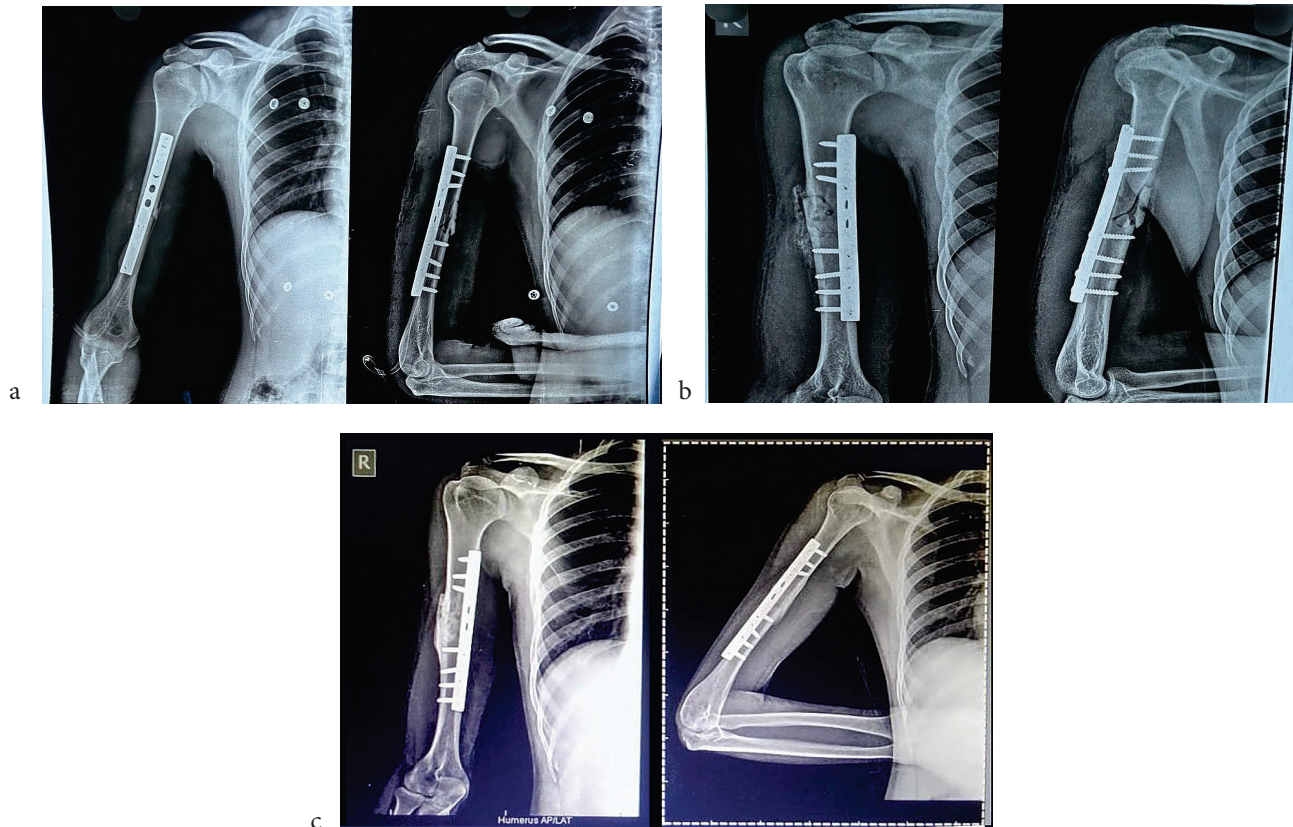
X-rays of patients
